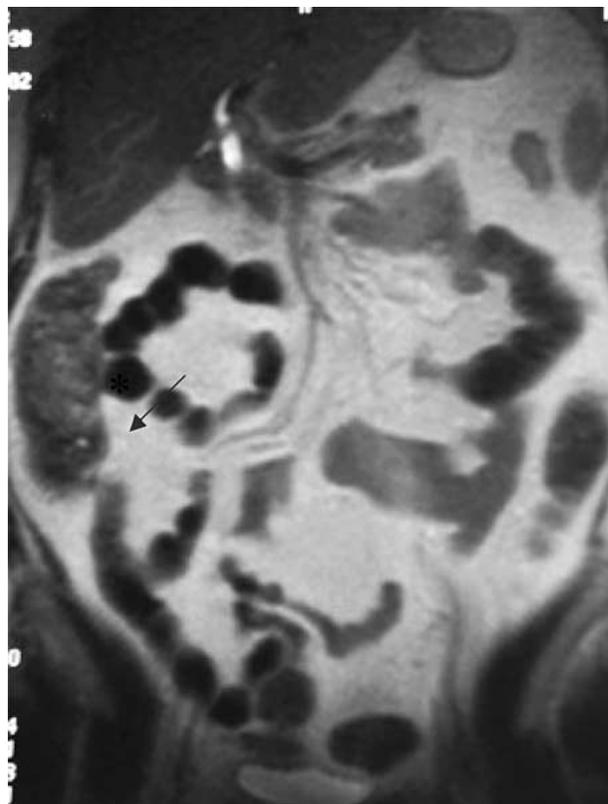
Sparing of the distal ileum and normal ileocecal valve. The normal appearance of the ileocecal valve (*asterisk*) and terminal ileum (*arrow*) are important findings to differentiate UC from CD and are clearly displayed on this T2-weighted half-Fourier single-shot turbo spin-echo coronal image that was obtained after oral administration of a superparamagnetic contrast agent.
